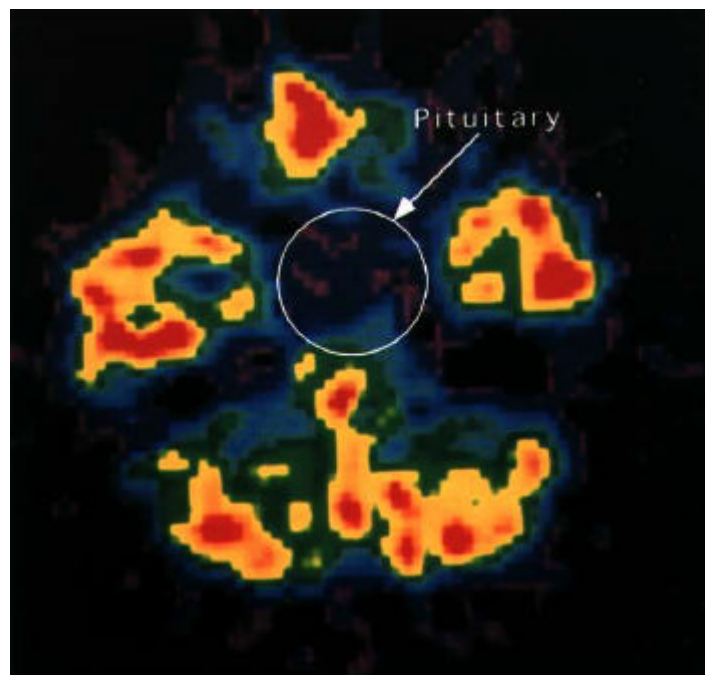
^{18}F -FDG PET image of case 3.
